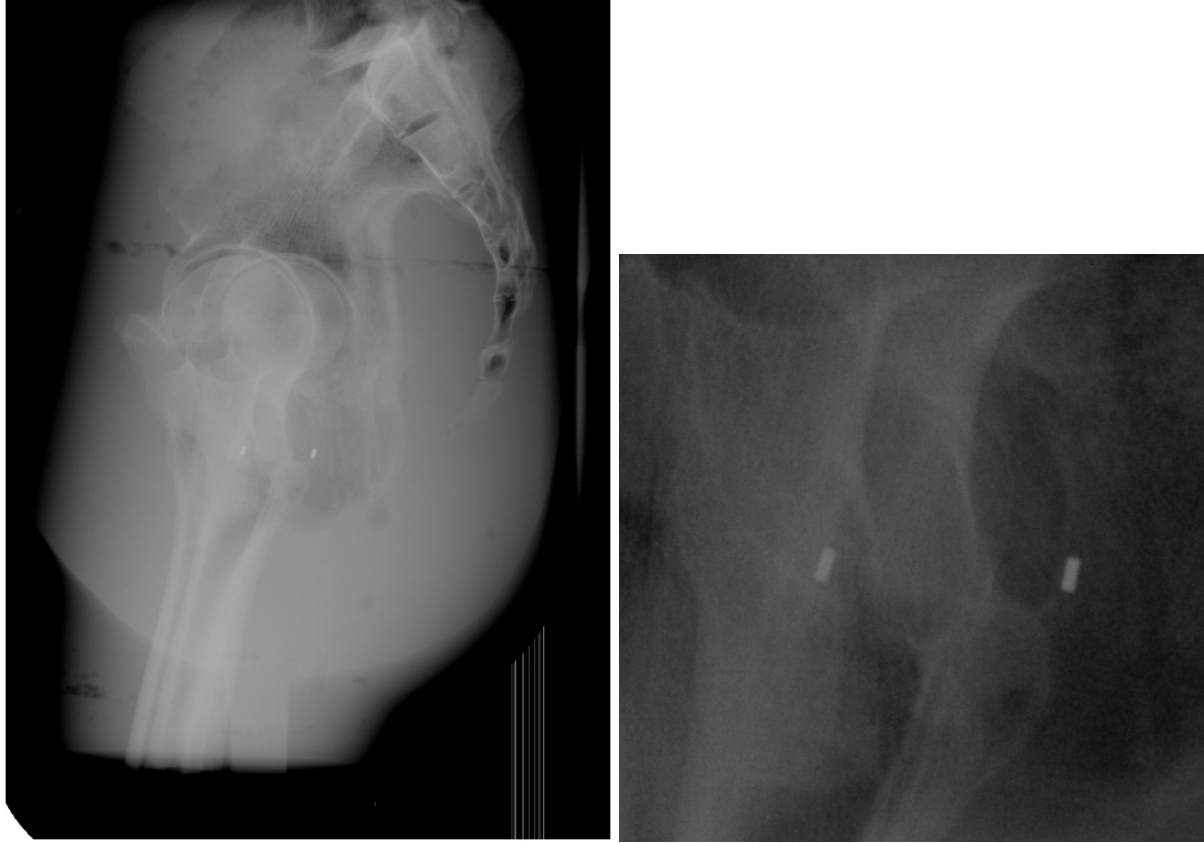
A typical x-ray projection image for the gold seeds 1.2x3 mm in the bone and soft tissues.
